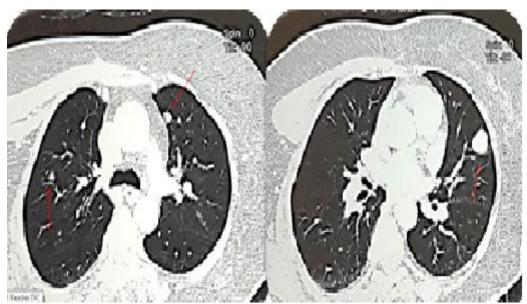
Chest CT scan demonstrating 2 unilateral metastasis benefiting from atypical resection.
